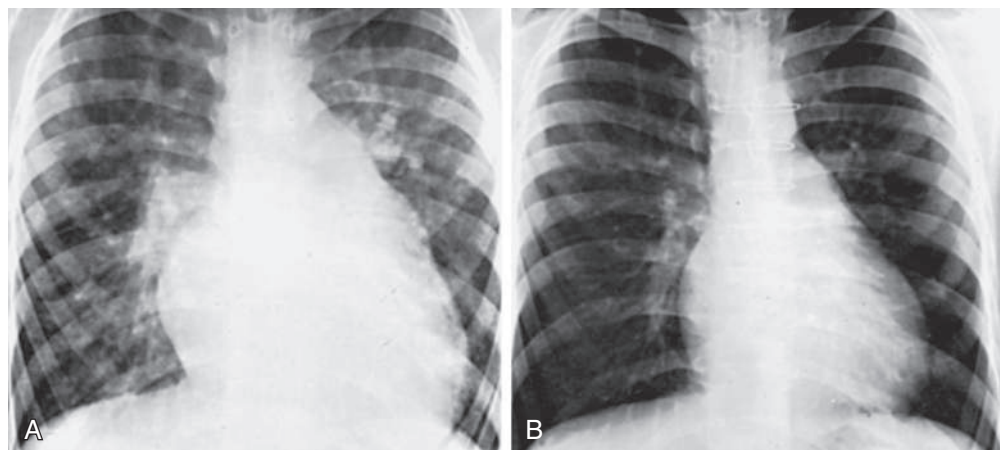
A, Preoperative radiograph in a patient with a ventricular septal defect with a large left-to-right shunt and pulmonary hypertension. Significant cardiomegaly, prominence of the pulmonary arterial trunk, and pulmonary overcirculation are evident. B, Three years after surgical closure of the defect, heart size is greatly decreased and the pulmonary vasculature is normal.
